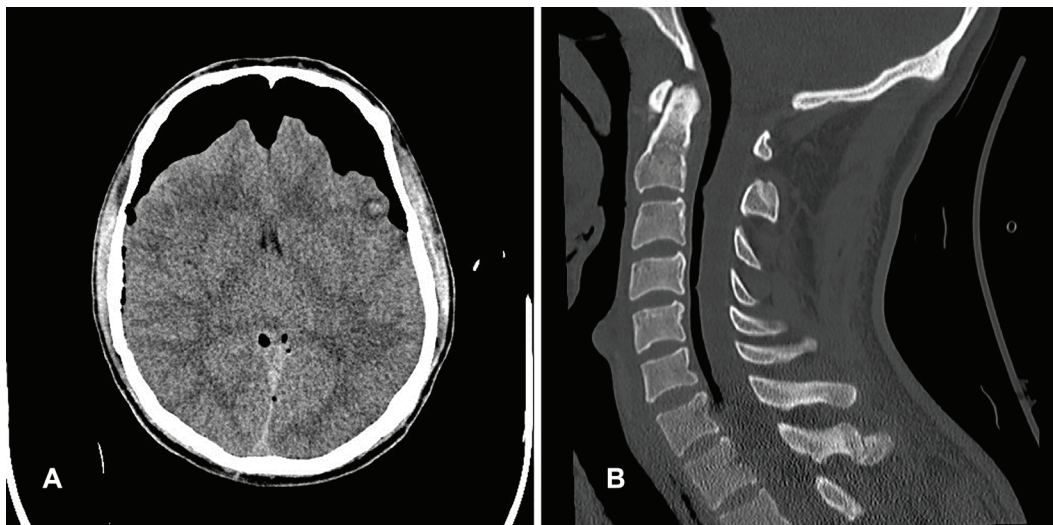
A) Axial brain CT-scan of the patient demonstrating so-called Fuji Mount sign in favor of massive pneumocephalus; B) Sagittal cervical CT-scan of the patient demonstrating massive pneumorrhachis at the anterior aspect of the dural sac descending to the C7 vertebra.
